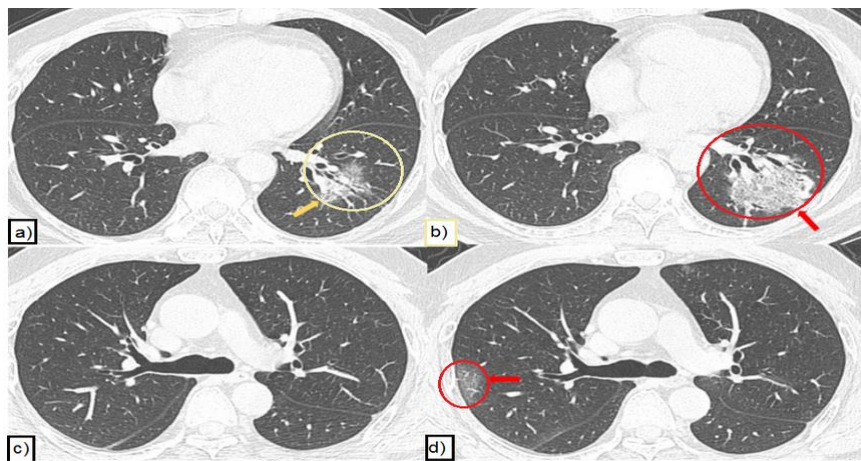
It shows the supervision of the infection by CT with axial sections of the chest region of a confirmed COVID - 19 patient
